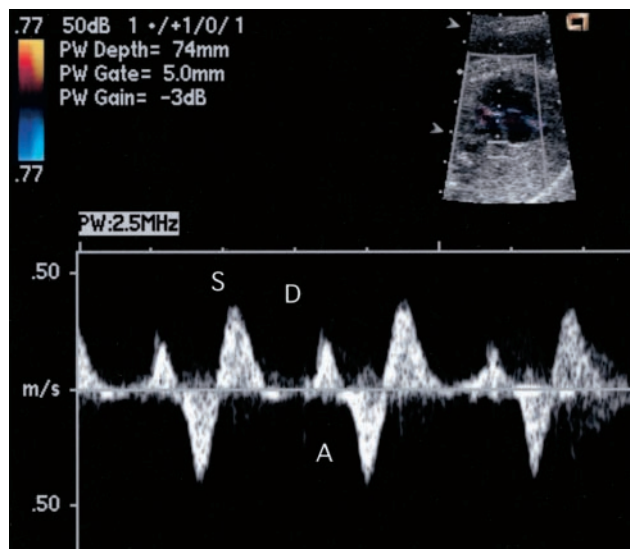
Pulmonary venous flow Doppler in fetus with intact atrial septum demonstrating flow reversal. S wave represents antegrade flow in pulmonary vein during ventricular systole; D wave, additional antegrade flow in diastole; and A wave, retrograde flow in pulmonary vein during atrial contraction.
